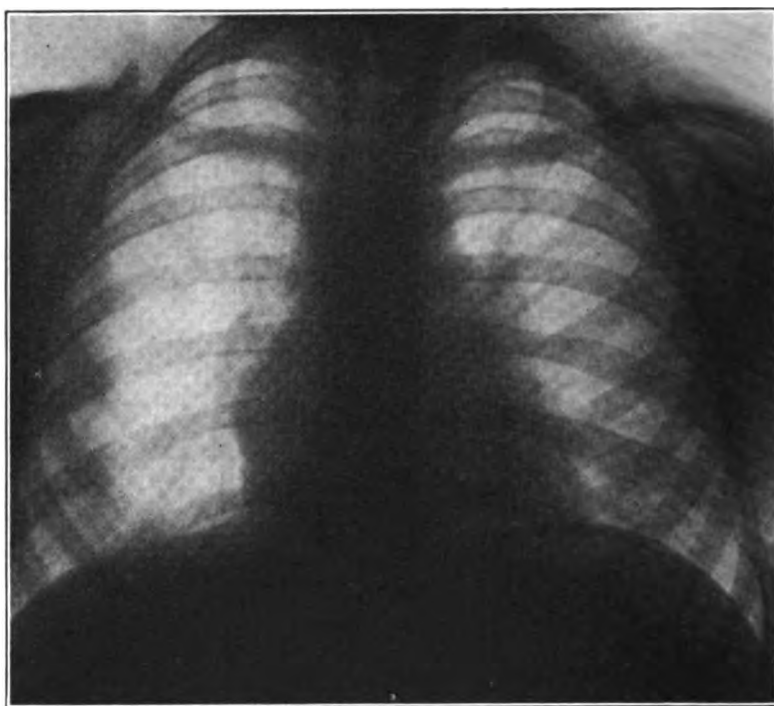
(Case 1). Radiograph taken November, 1915. Absence of all infiltration.
